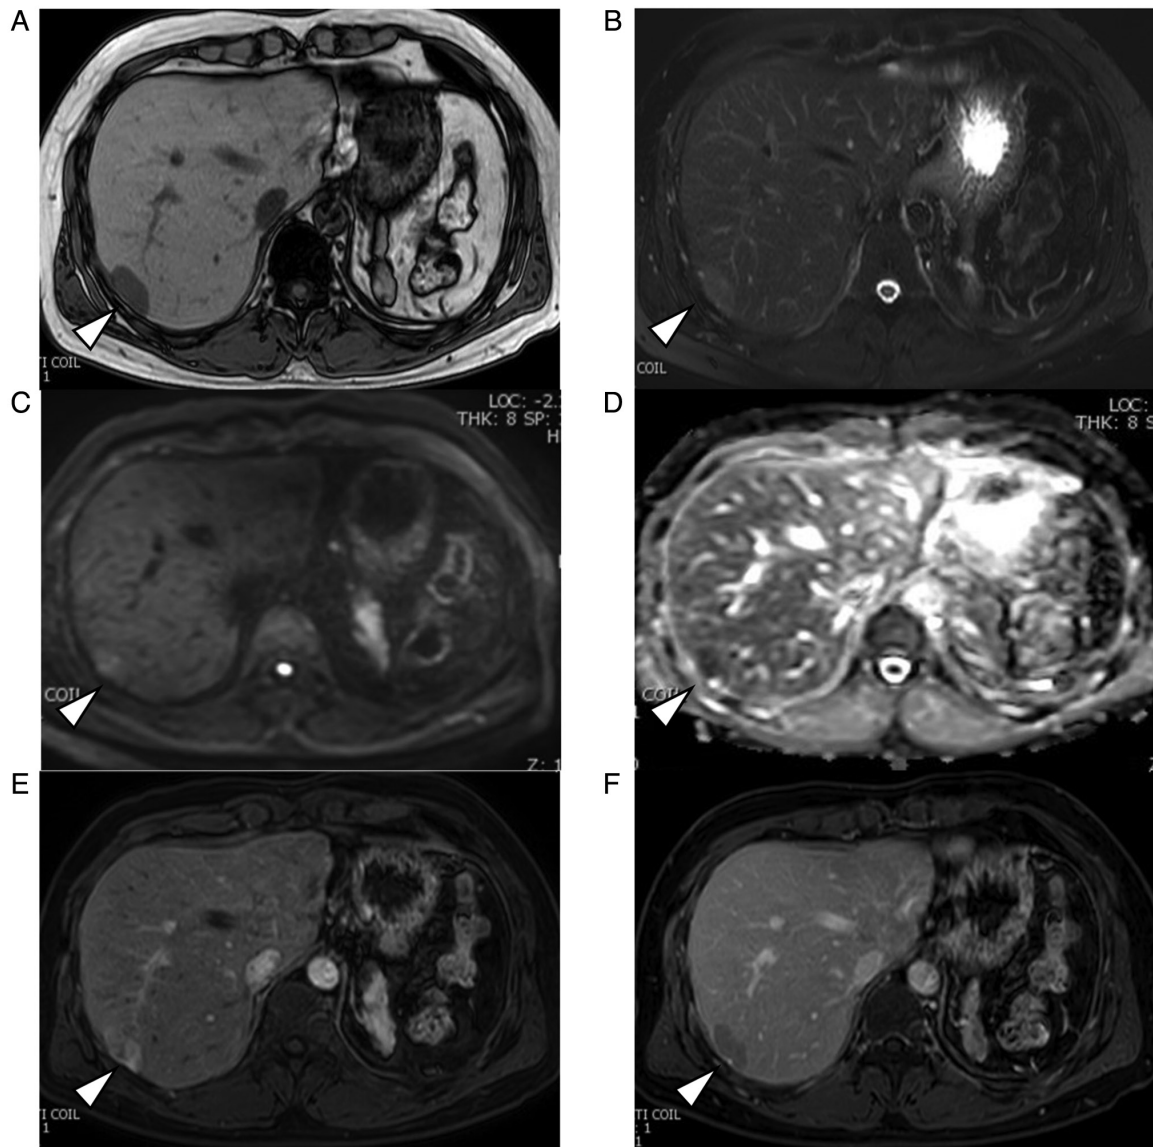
Magnetic resonance imaging of the IHS (arrows). The IHS was detected with (A) a homogeneous hypointensity in T1-weighted images, (B) slight hyperintensity in T2-weighted images. (C) Lesion showed a heterogeneous hyperintensity in diffusion-weighted images and (D) signal reduction in apparent diffusion coefficient. After the injection of gadoxetic acid, (E) the lesion appeared heterogeneously hyperintense during the early phase and (F) relatively hypointense during the delayed phase. HIS, intrahepatic splenosis.
